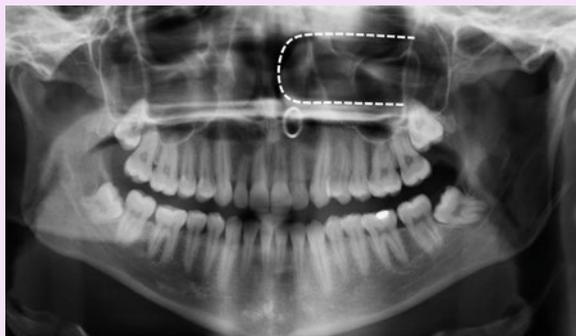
The superimposition of the inferior nasal concha on this dental panoramic radiograph has resulted in an artefactual radiopaque appearance of the maxillary sinus. The left nasal piercing is projected superior to the upper left incisors
